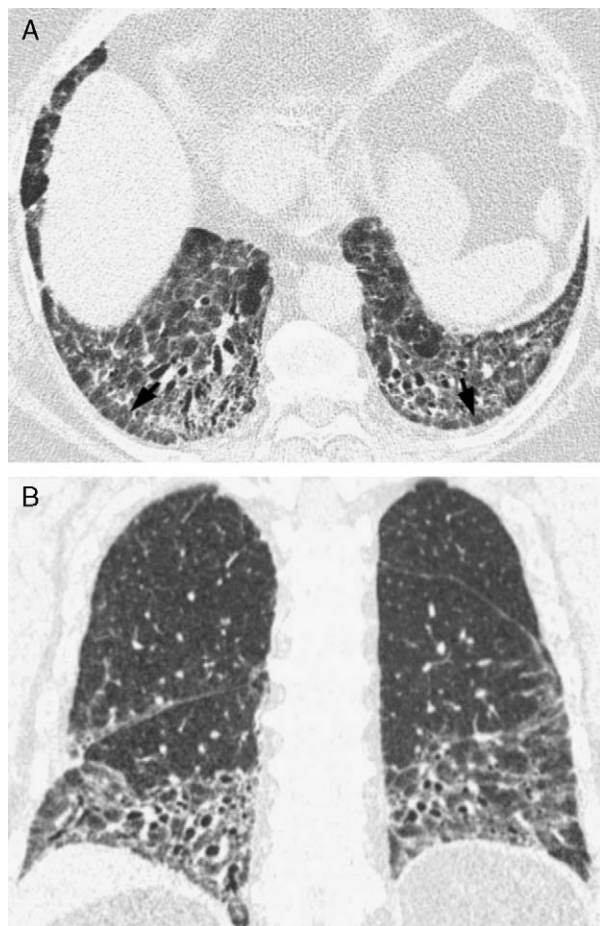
Nonspecific interstitial pneumonia in a 71-year-old woman. A, HRCT image at the level of the lung bases shows extensive bilateral ground-glass opacities, reticulation, and traction bronchiectasis. Note relative sparing of the lung (arrowheads) immediately adjacent to the pleura in the dorsal lung regions of the lower lobes (relative subpleural sparing). Although there is ground-glass opacity in the subpleural lung, the reticulation and traction bronchiectasis are approximately 1 cm away from the pleura. B, Coronal reformation image shows ground-glass opacities, reticulation, and traction bronchiectasis mainly in the lower lung zones.
